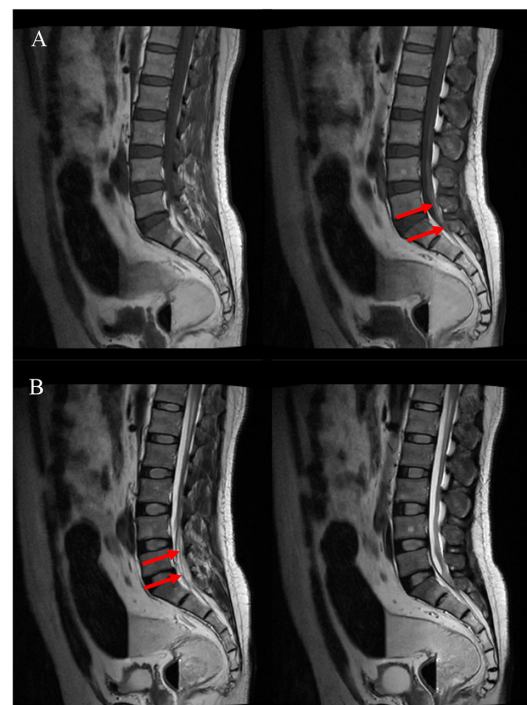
Weighted MRI of the patient's lumbosacral spine 4 days after the surgery. (A) T1-weighted and (B) T2-weighted MRI images. The lumbosacral spine MRI scan indicated a slight hematoma in the subarachnoid space below the L2 level, as indicated by the red arrow. MRI, magnetic resonance imaging.
